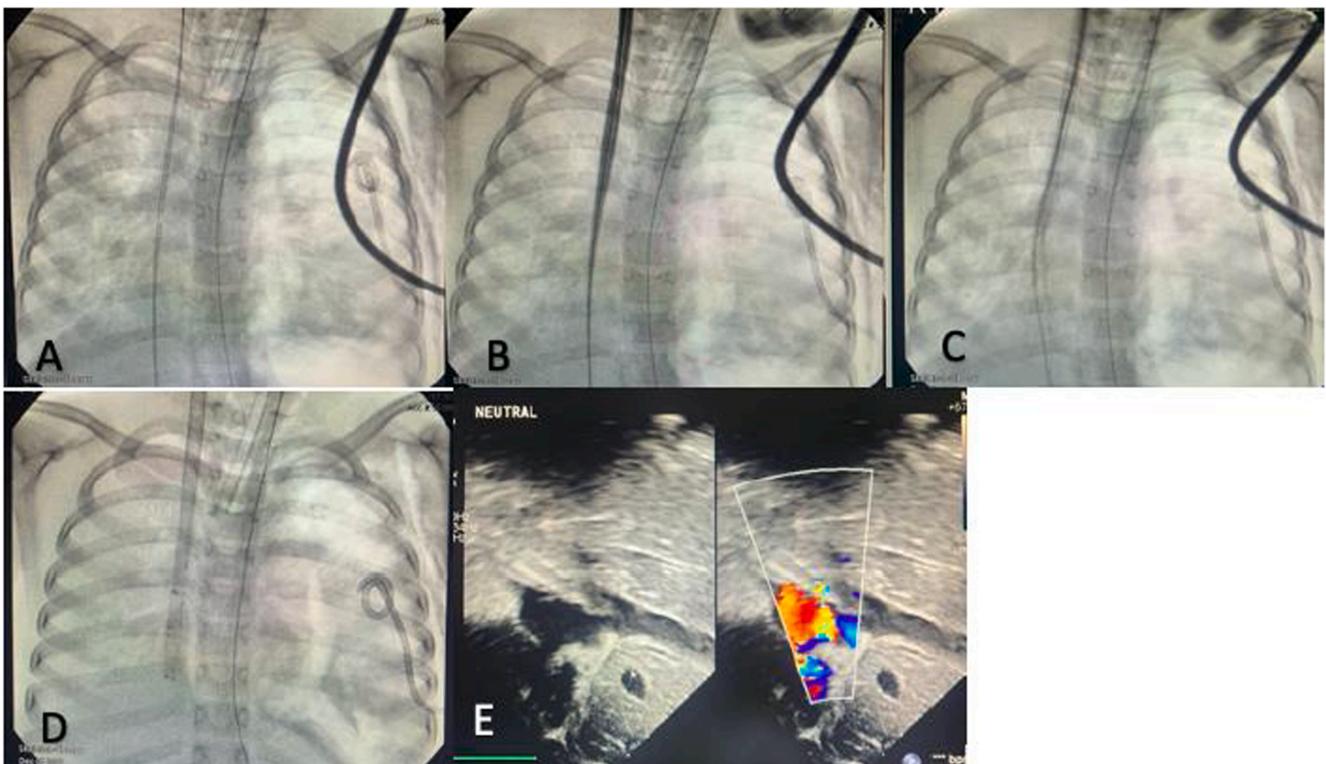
Image guided VV ECMO dual lumen atrial ECMO cannulation (A) proper positioning of the ECMO guidewire in the IVC under fluoroscopic guidance. (B) Dilatation of the venotomy with serial dilators. (C/D) Placement of the VV catheter under fluoroscopy. (E) Echocardiography demonstrating appropriate position and flow.
